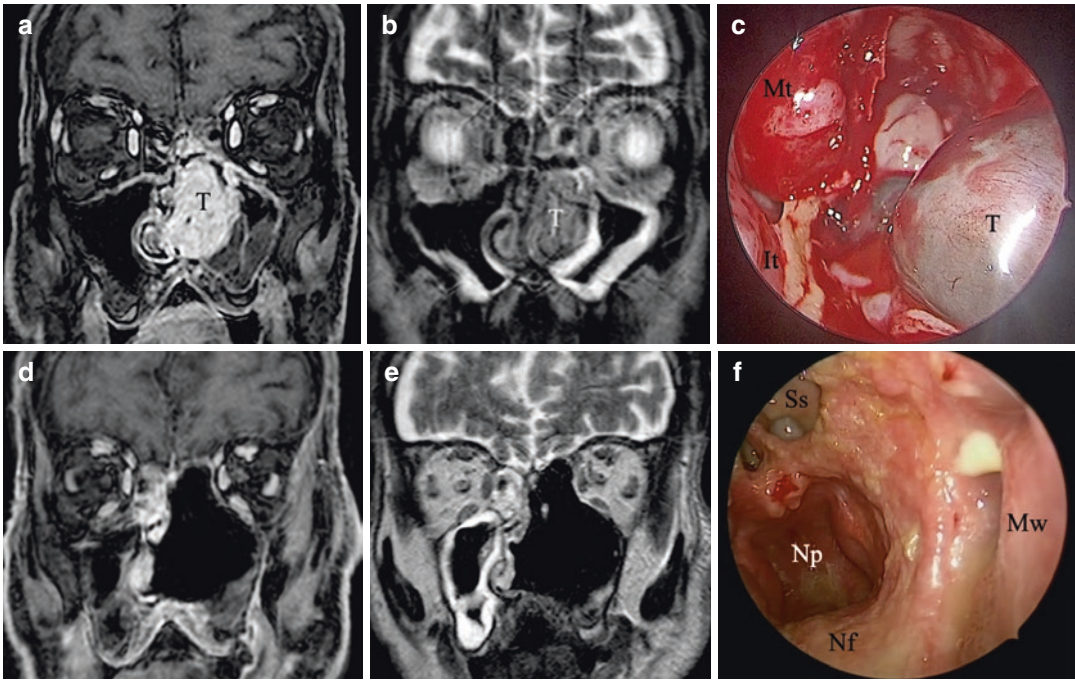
A 71-year-old male affected by left nasal fossa mucosal melanoma T3N0M0. Preoperative MRI scans in coronal views ((a) T1W with contrast; (b) T2W) show the tumour occluding the left nasal fossa and infiltrating the nasal septum. The patient underwent a left transnasal endoscopic medial maxillectomy type IIIb with removal of the nasal septum and drilling of the hard palate. Intraoperative view (c) shows the tumour in the left nasal
